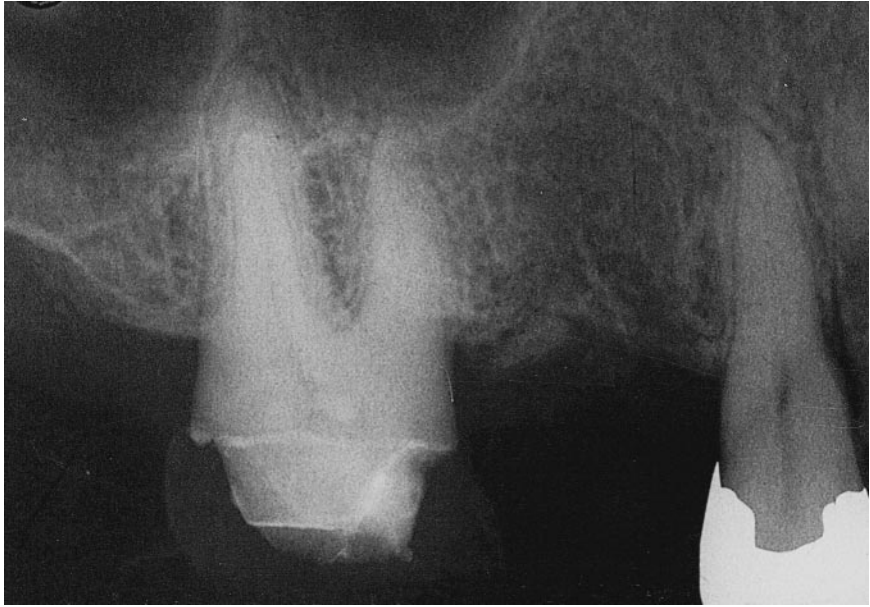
A periapical radiograph after 3 months demonstrates a lack of residual lamina dura and complete healing.
